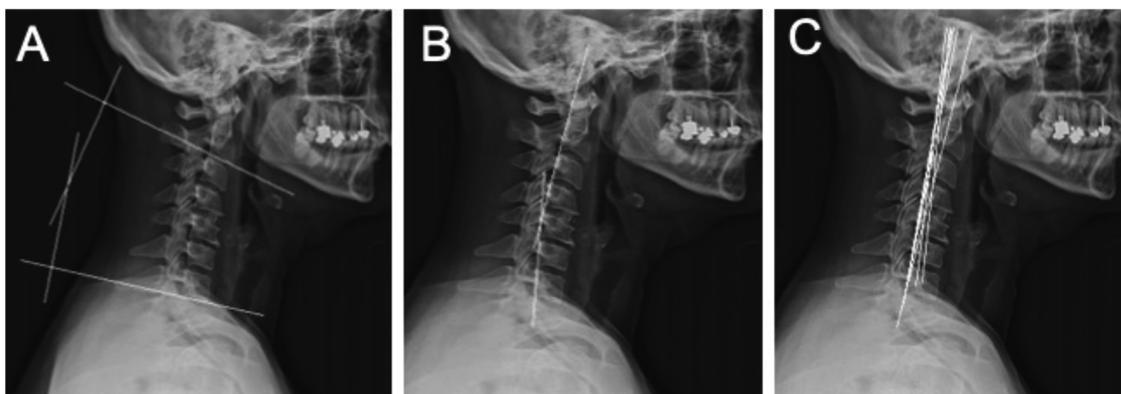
Cervical lordosis calculation methods on lateral x-rays. A) Cobb method. B) Harrison method. C) Jackson method.
